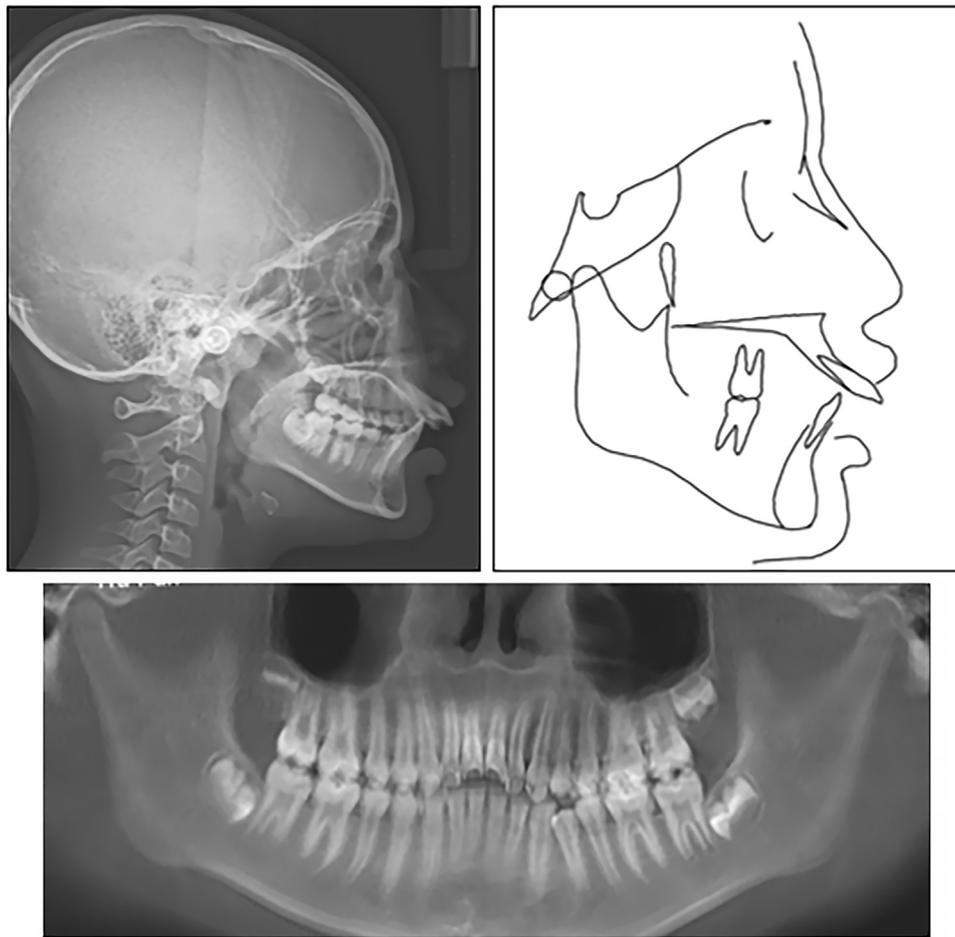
Pretreatment cephalogram, tracing, and panoramic radiograph.
